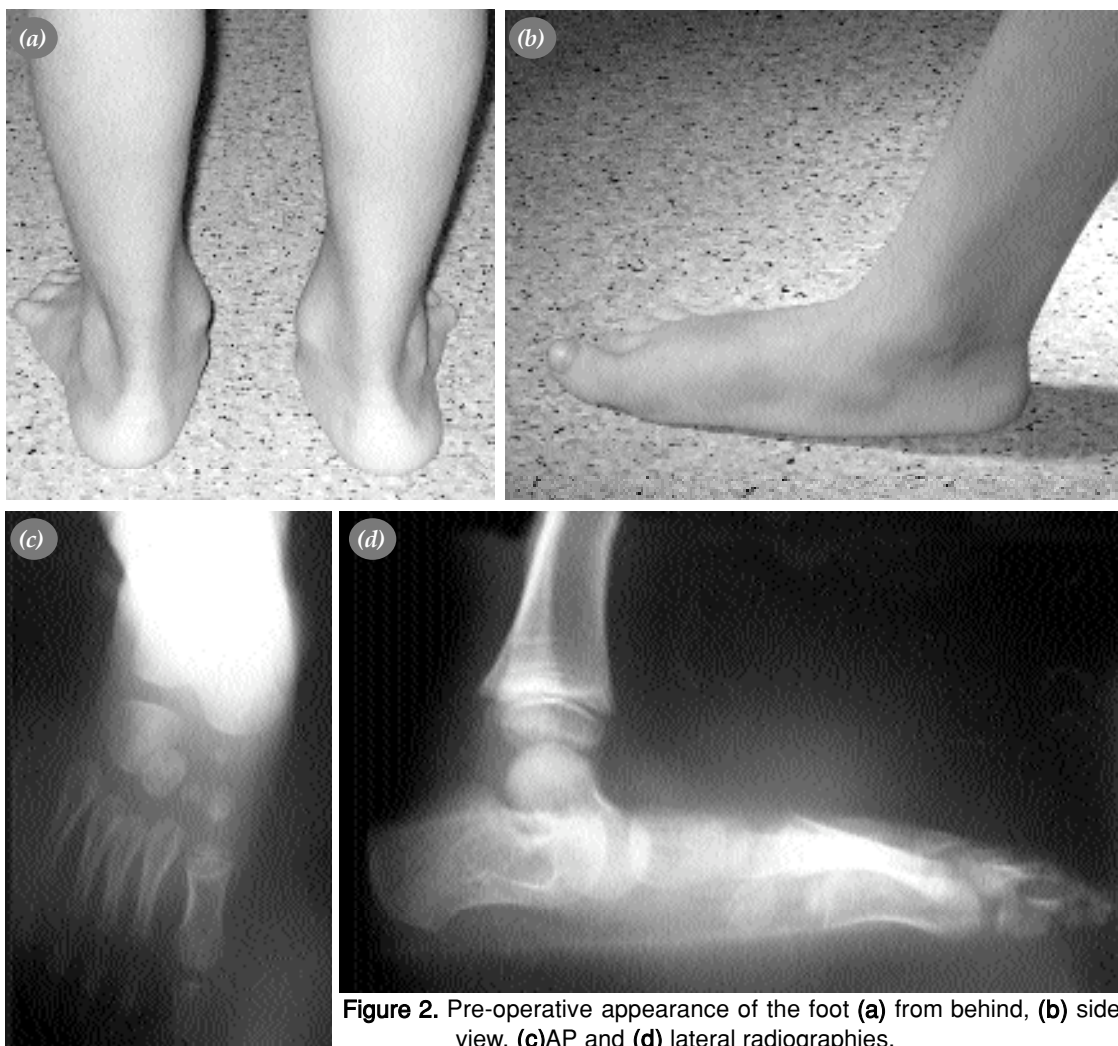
Pre-operative appearance of the foot (a) from behind, (b) side view, (c) AP and (d) lateral radiographies.
